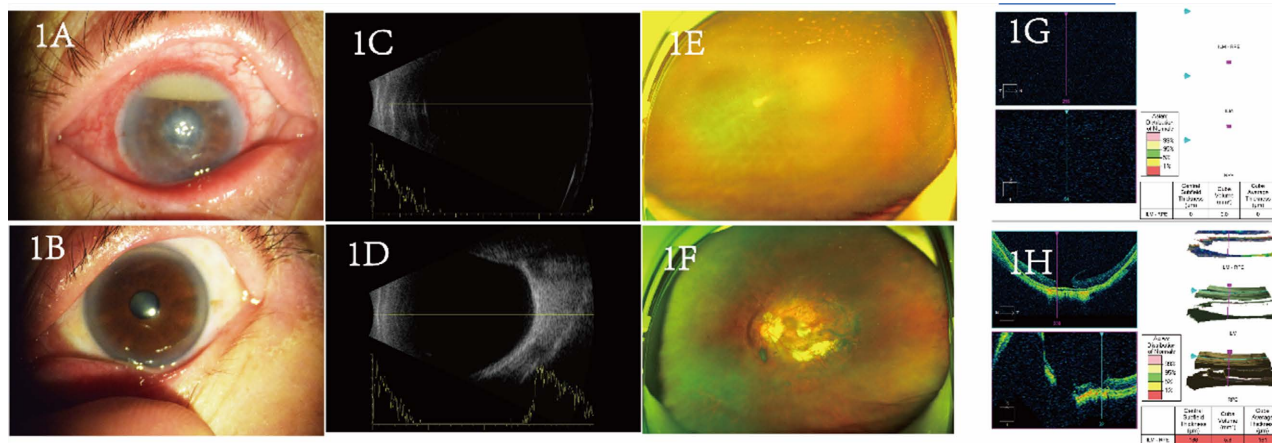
The patient underwent anterior segment photography, ocular ultrasound, fundus photography and macular OCT before silicone oil removal. (1(A), 1(C), 1(E), 1(G): right eye; 1(B), 1(D), 1(F), 1(H): left eye).
